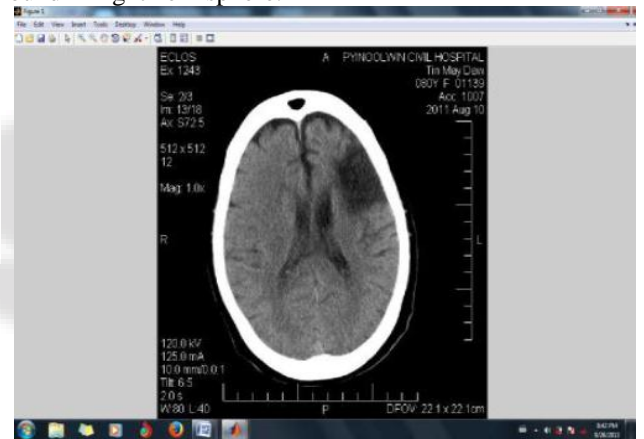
Original CT image
